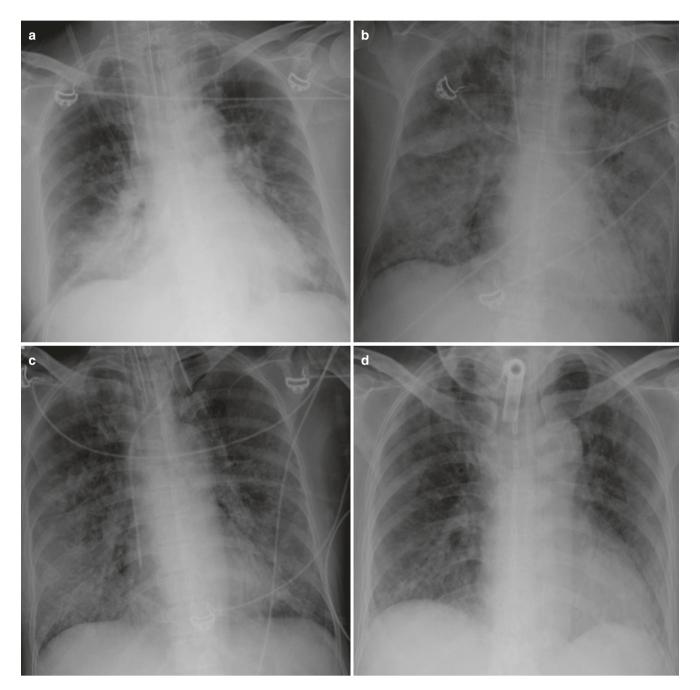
Acute respiratory distress syndrome (ARDS). (a) AP bedside chest radiograph of a patient admitted to ICU with severe pneumonia demonstrates dense right lower zone consolidation from pneumonia, (b) rapidly progressing to extensive bilateral central consolidation
